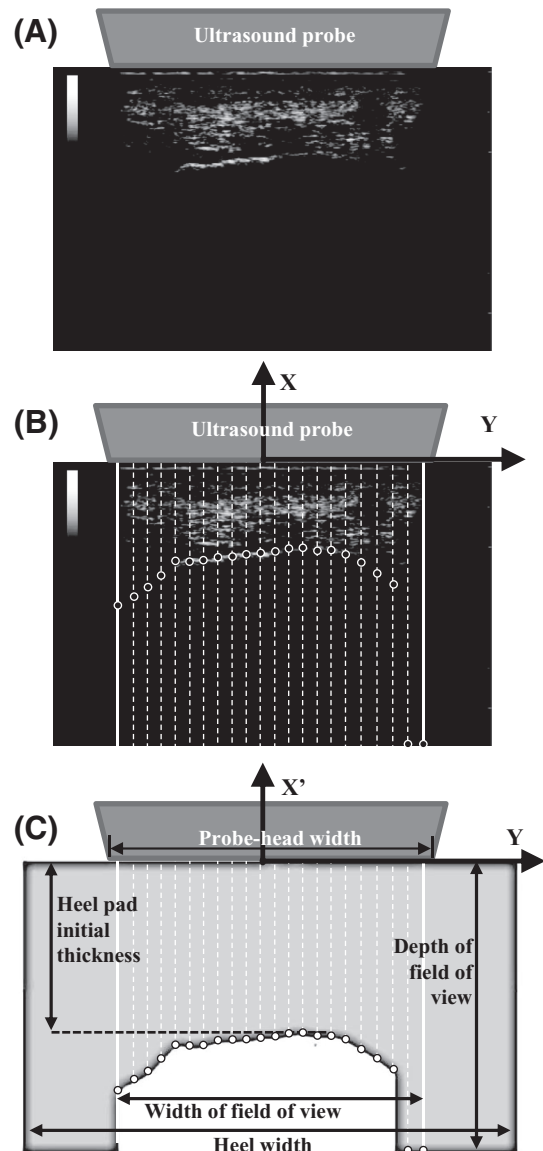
(A) The frontal ultrasound image of the heel that was used for the reconstruction of the geometry of the calcaneus. (B) Using Matlab the ultrasound image is divided by a series of line segments with a relative distance of 2 mm. These lines are used as search paths to identify the transition points between bone and soft tissue. When imported into ANSYS the coordinates of these key points are utilised to create a polynomial line that outlines the calcaneus. (C) The geometry of the final FE model of the indentation test.
